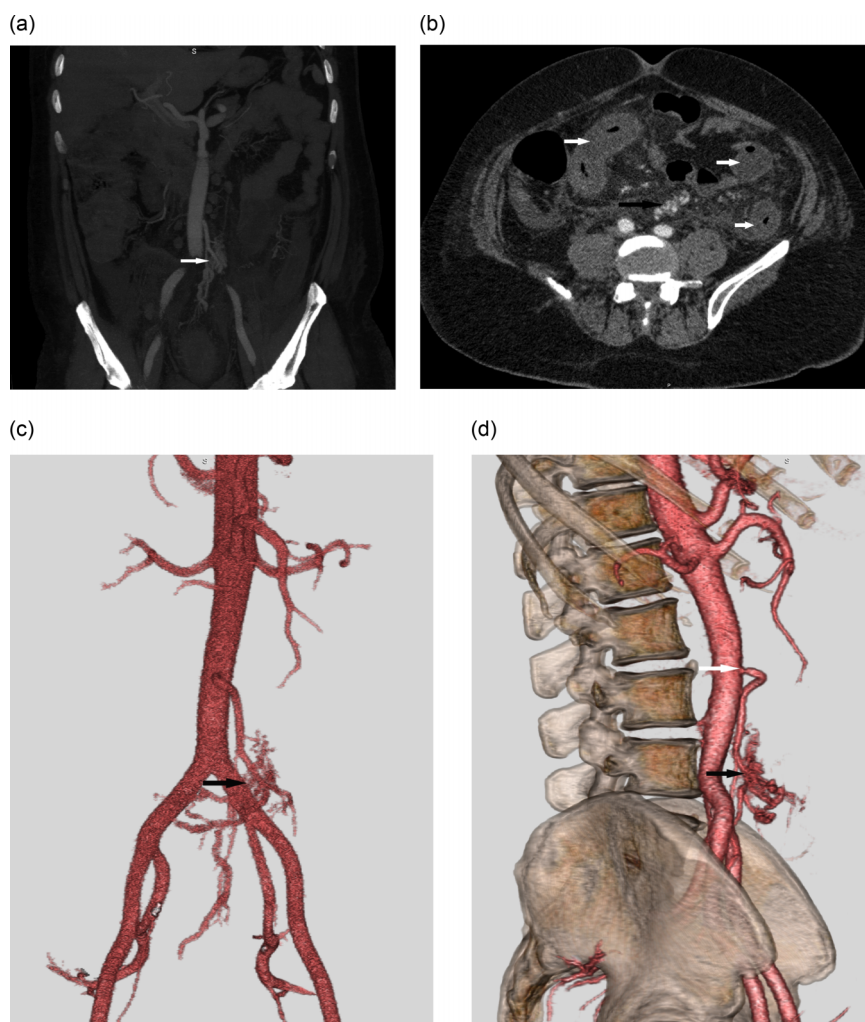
(A) Coronal maximum intensity projection CT angiography image shows arteriovenous malformation originating from inferior mesenteric artery (arrow). (B) Axial CT image shows multiple abnormal vascular structures around to inferior mesenteric artery (black arrow) and marked thickening of colonic wall segments (white arrows). Frontal (C) and lateral (D) views of coloured three-dimensional volume rendered CT angiography images show arteriovenous malformation nidus (black arrow) of inferior mesenteric artery (IMA) (C and D) and severe stenosis of orifice of the IMA (white arrow).
